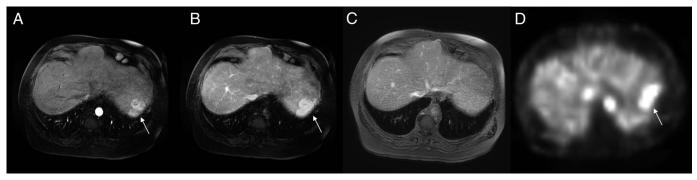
(A) Dynamic arterial phase, (B) portal venous phase, and (C) 5-minute delayed phase T1-weighted postcontrast axial magnetic resonance imaging revealed arterial and portal venous enhancement and delayed wash out of the liver lesion (arrow). (D) Axial single-photon emission computed tomography image revealed increased uptake (arrow) within the left lobe of the liver consistent with splenosis.
